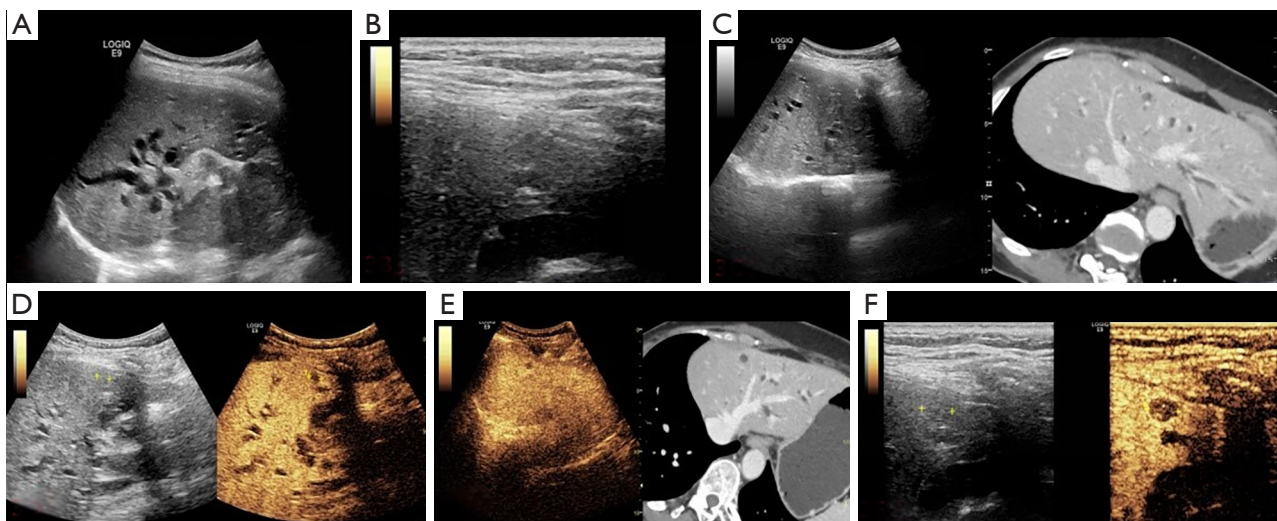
Scans of a 52-year-old female patient with elevated AFP and CA199 levels on laboratory examination. (A) Gray-scale ultrasound showed multiple hypoechoic masses in the abdominal, mild dilation of intrahepatic bile ducts, but no obvious liver lesions. (B) Despite using a high-frequency probe, no significant liver parenchymal masses were observed. (C) After MR-US fusion imaging, multiple anechoic areas were visible within the liver, but no apparent solid masses were seen. (D) Following the administration of 0.6 mL of Sonazoid contrast agent, a low-enhancement lesion measuring approximately 0.8 by 0.7 cm was observed in the arterial phase, and the lesion beneath the hepatic capsule of the right anterior lobe. (E) MR-CEUS fusion imaging confirmed that the location of the lesion corresponded to the position indicated on MR imaging. (F) During the hepatocyte phase, a high-frequency ultrasound examination was performed, and the lesion still displayed hypoechoic changes. Subsequently, a percutaneous liver biopsy was conducted under the guidance of CEUS-high-frequency ultrasound. The pathological result confirmed metastatic adenocarcinoma, which was consistent with the final diagnosis. AFP, alpha-fetoprotein; CA199, carbohydrate antigen 199; MR, magnetic resonance; US, ultrasound; CEUS, contrast-enhanced ultrasound.
